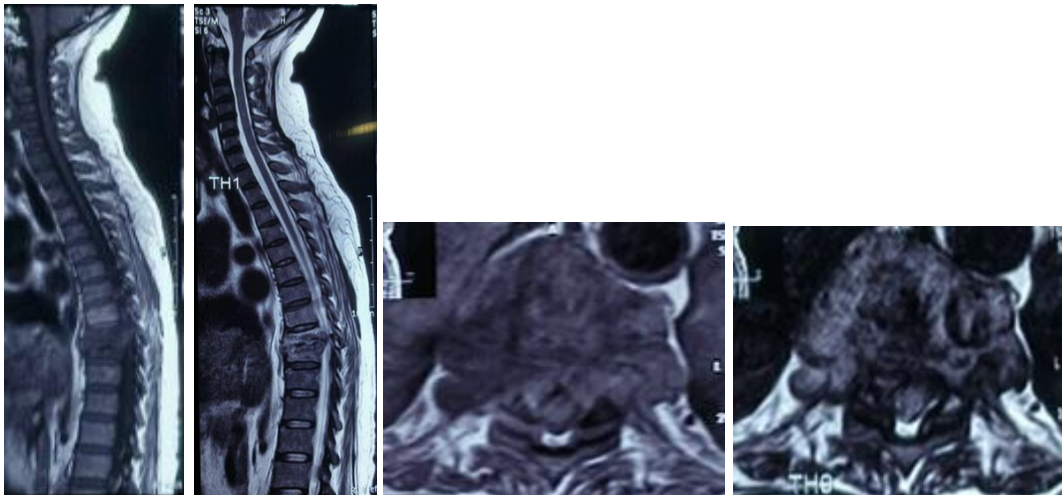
MRI Vertebrae T1-T2 sagital and axial, Burst Fracture Th9-10 with canal stenosis.
